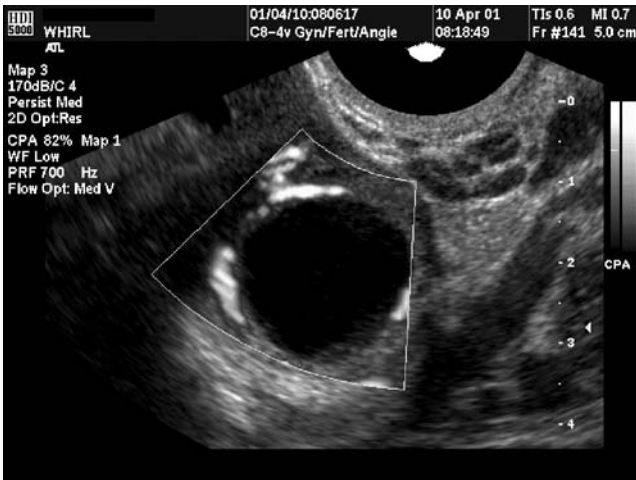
Power-flow Doppler image of a dominant preovulatory follicle showing the perifollicular vascularization consistent with follicular maturity.
